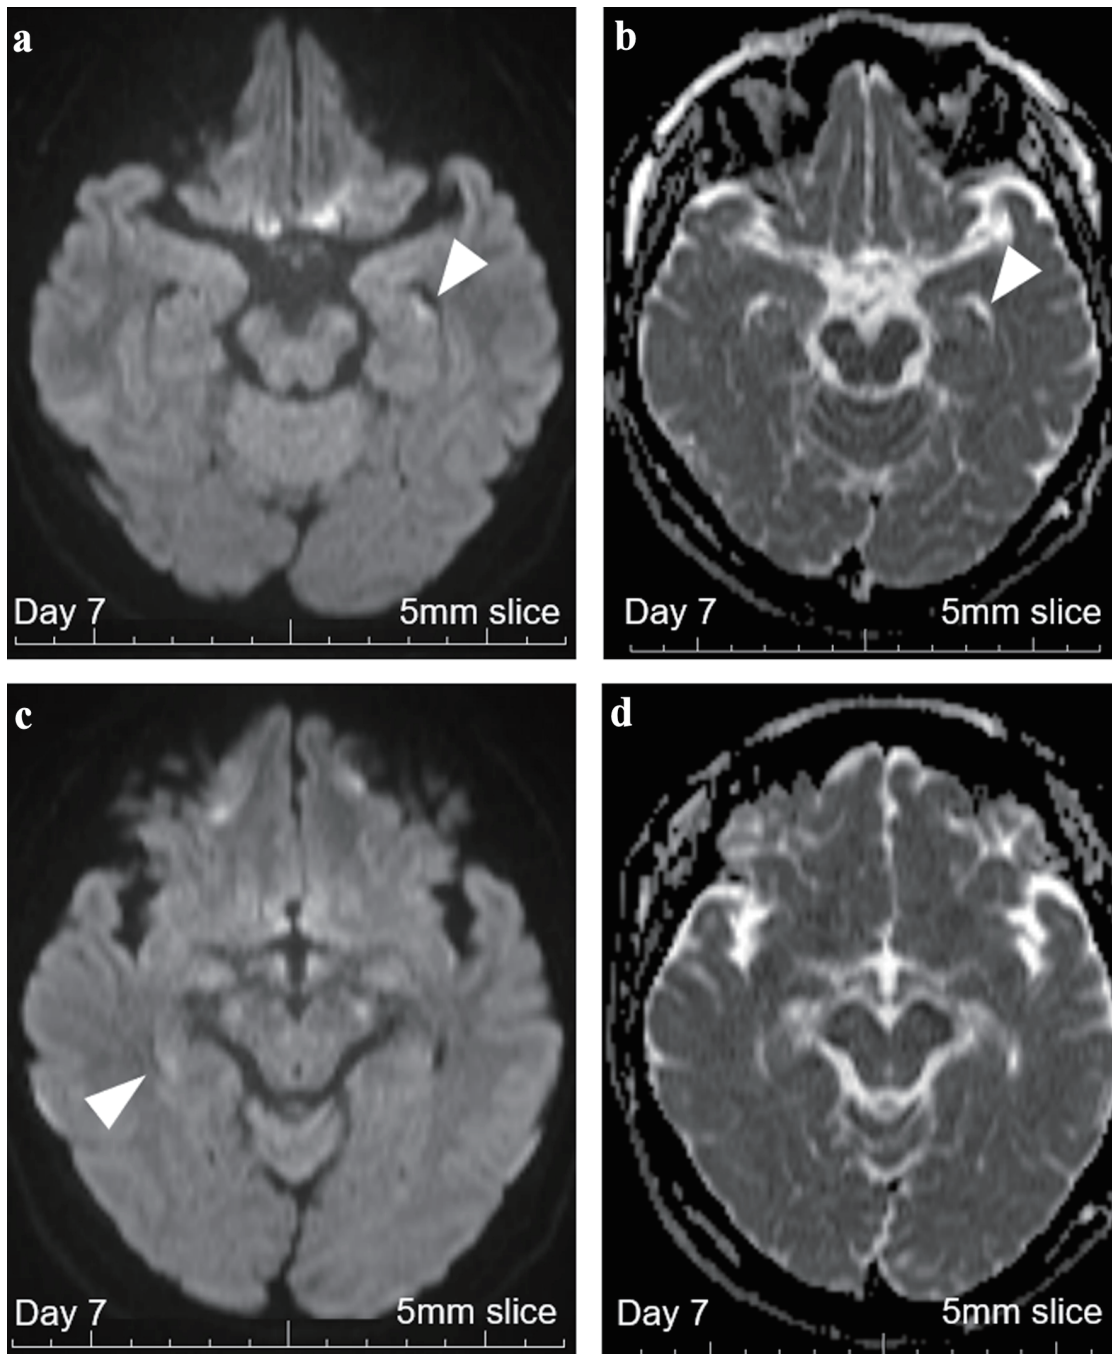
Brain MRI with 5-mm thickness on day 7. (a) DWI with 5-mm-thick brain MRI on day 7 revealed persistent high signals in the left hippocampus (white arrowhead), increasing the probability of hippocampal infarction. (b) ADC with 5-mm-thick brain MRI on day 7 revealed persistent signal loss in the left hippocampus (white arrowhead). (c) DWI with 5-mm-thick brain MRI on day 7 revealed persistent vague high signals in the right hippocampus (white arrowhead). (d) ADC with 5-mm-thick brain MRI on day 7 revealed no apparent signal loss, suggesting that cellular damages were milder on this side. MRI: magnetic resonance imaging; ADC: apparent diffusion coefficient; DWI: diffusion-weighted imaging.
